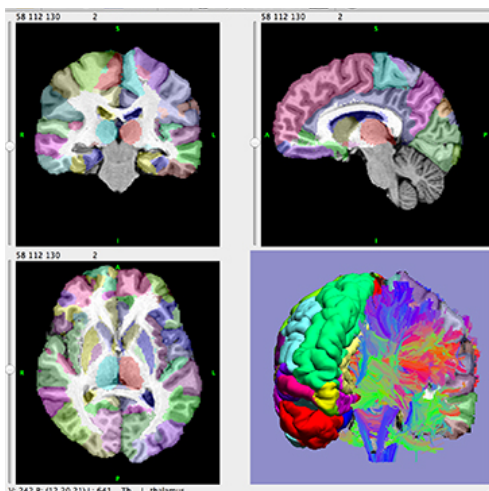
MR image analyzed by BrainSuite (7)
